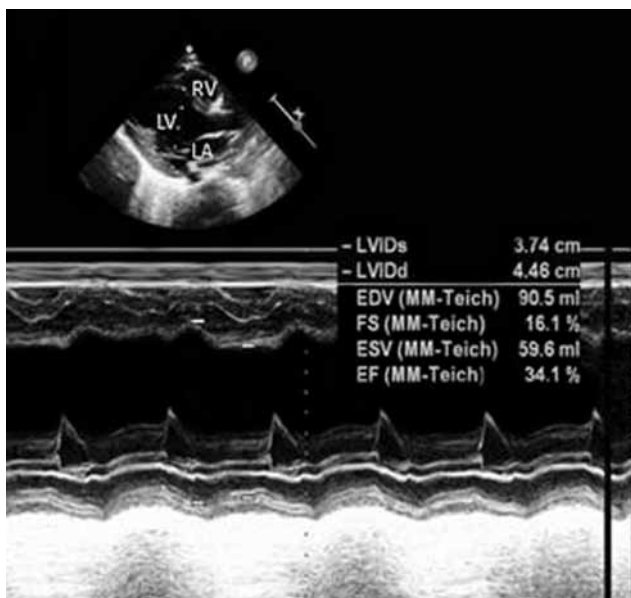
Preoperative transthoracic echocardiographic M-mode evaluation of the left ventricle.
